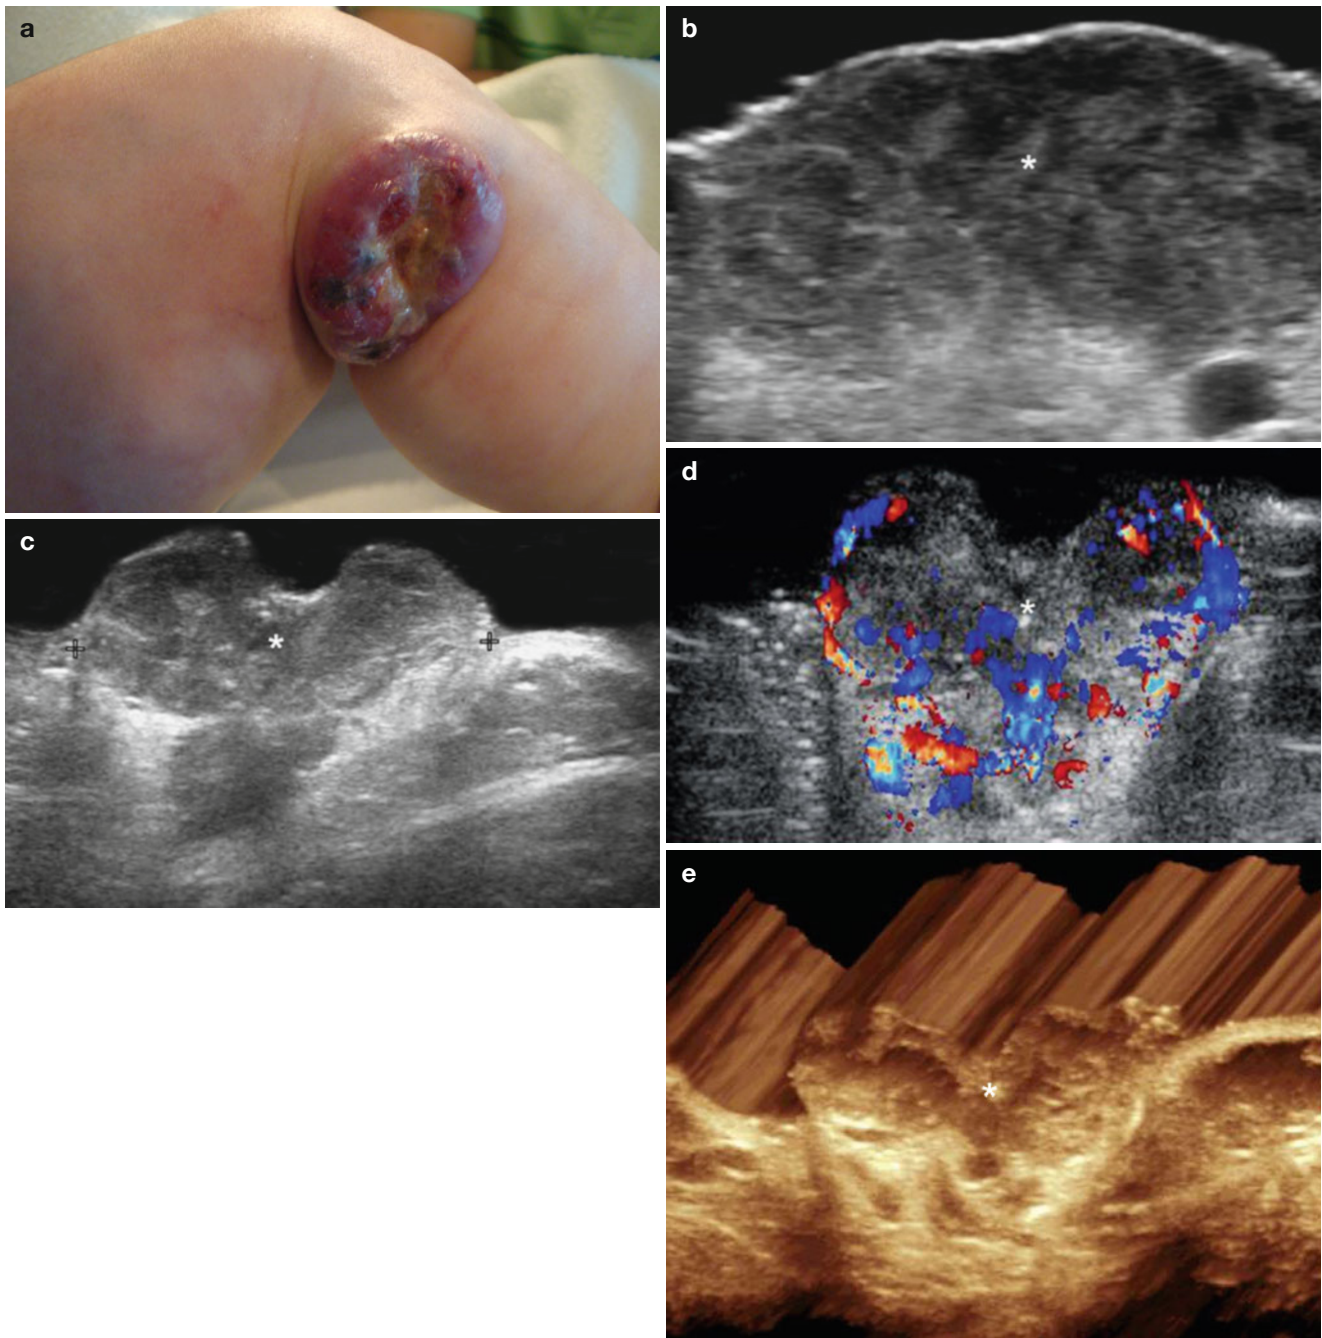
(a–e) RICH (Rapidly involuting congenital hemangioma). (a) Clinical image of an ulcerated RICH lesion in the leg (male baby, 2 months old). (b) Ultrasound image (gray scale, transverse view) shows hypoechoic and slightly heterogenous lesion (*) that involves all the cutaneous layers. Notice the increased hyperechogenicity in parts of the epidermis and the hypoechogenicity of the dermis and subcutaneous
